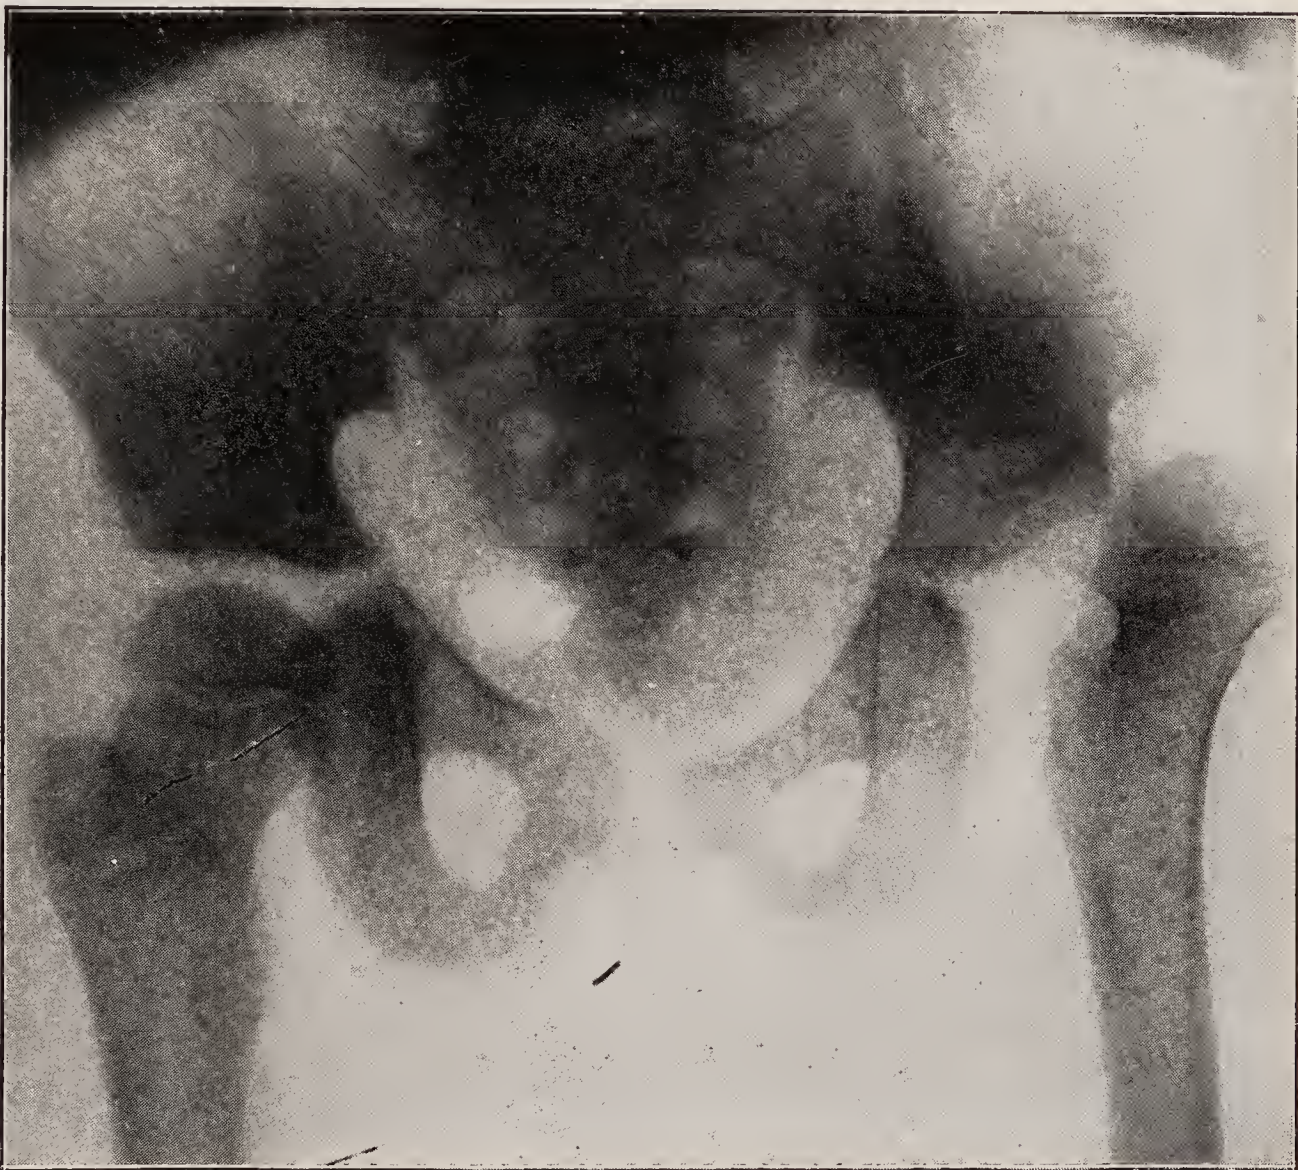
X-ray of a paralytic dislocation of the left hip.
